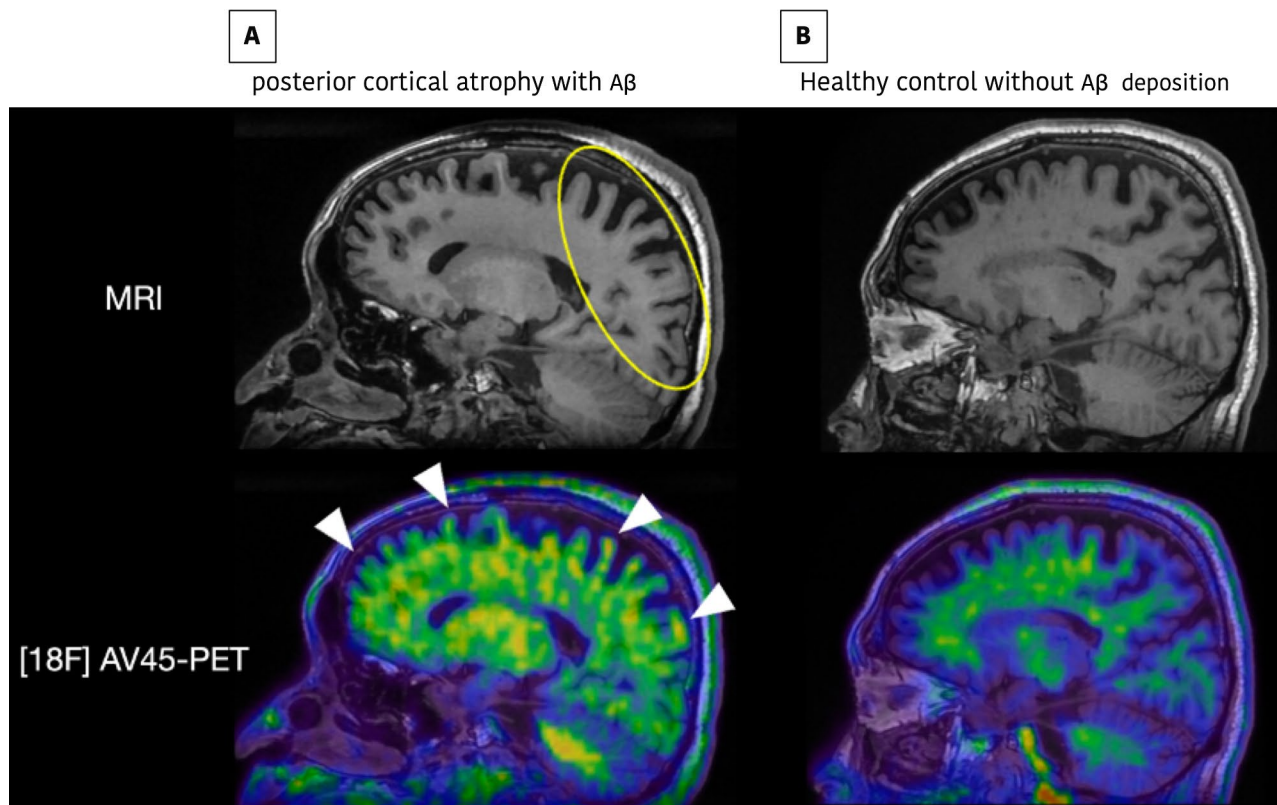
Representative sagittal 18 F-AV45 PET/MRI images. (A) A participant with PCA with significant cortical amyloid- β ($A\beta$) deposition (white arrows) and occipital-parietal atrophy of right hemisphere in brain MRI (yellow circle). (B) An age and sex matched healthy control participant with typical negative 18 F AV45-PET scan and MRI scan indicates no significant occipital-parietal atrophy
